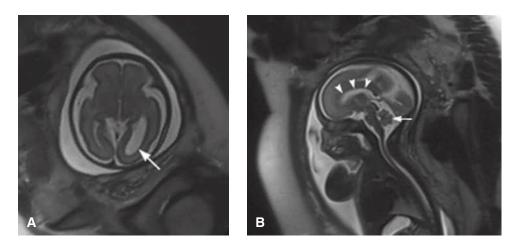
Nullipara with a 27 weeks' gestation. A. Axial T2-weighted MR image shows mild fetal unilateral ventriculomegaly involving the left lateral ventricle (*arrow*). B. Sagittal T2-weighted MR image demonstrates normal development of the corpus callosum (*arrowheads*) and vermis (*arrow*).
